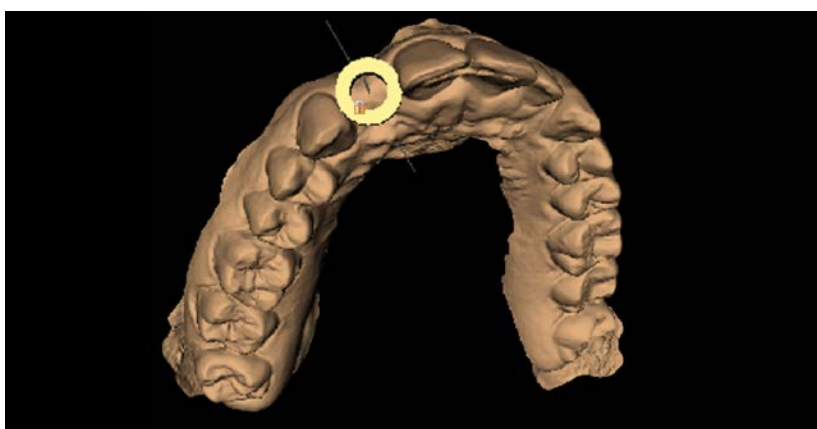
CBCT scan examination in implant planning software revealed a ridge of minimal bone thickness, ~5 – 6 mm at minimum. Without a drill guide this would have been a very difficult procedure to complete predictably without the need for grafting.
